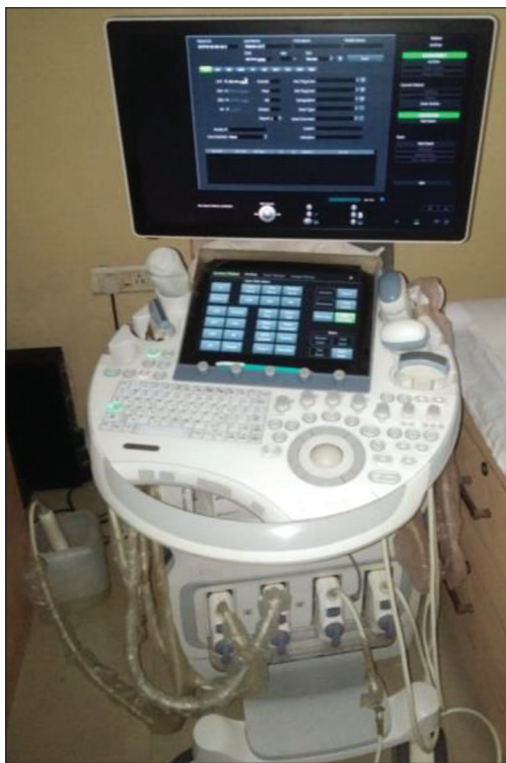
Ultrasound machine
